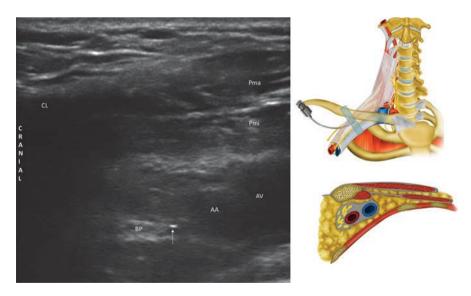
Ultrasound of infraclavicular/costoclavicular progressing needle tip until it was concealed under the clavicle shadow. *BP* – brachial plexus; *AA* – axillary artery; *AV* axillary vein; *Pma* pectoralis major; *Pmi* pectoralis minor; *CL* clavicle; arrow – needle
